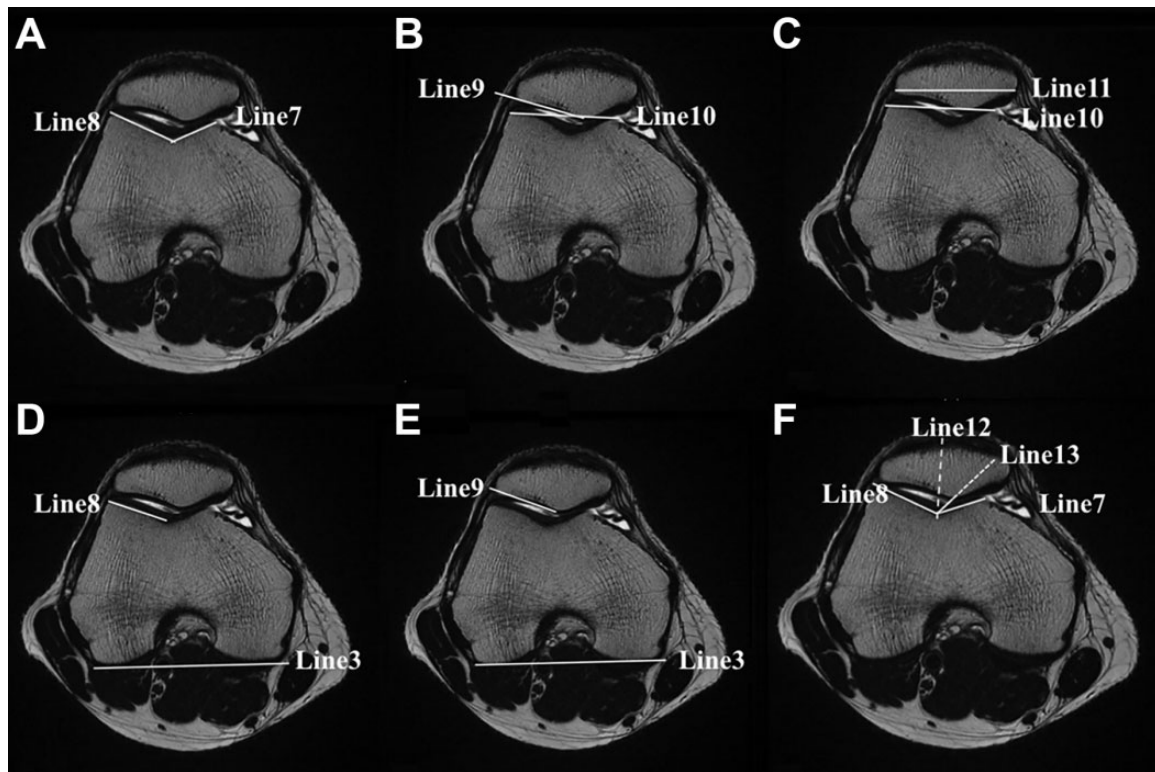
Patellofemoral (PF) angles measured on magnetic resonance imaging scans. (A) The PF sulcus angle is the angle between a line drawn between the most anterior part of the medial condyle and the deepest part of the trochlea (line 7) and a line drawn between the most anterior part of the lateral condyle and the deepest part of the trochlea (line 8).^{14,27} (B) The lateral PF angle is the angle between a line drawn parallel to the lateral patellar facet (line 9) and a line drawn connecting the most anterior points of the medial and lateral condyles (line 10).²¹ (C) The patellar tilt angle is the angle between a line connecting the medial and lateral corners of the patella (line 11) and a line that joins the highest points of the femoral condyles (line 10).³⁶ (D) The lateral trochlear inclination angle is the angle between the lateral trochlear facet (line 8) and a tangential line (line 3) through the posterior femoral condyle.³ (E) The lateral patellar tilt angle is the angle formed by lines 9 and 3. (F) The PF congruence angle is the angle between a line bisecting the trochlear sulcus (line 12 is the bisector of lines 7 and 8) and a line (line 13) connecting the deepest part of the trochlea and the edge of the inferior tip of the patella.¹
